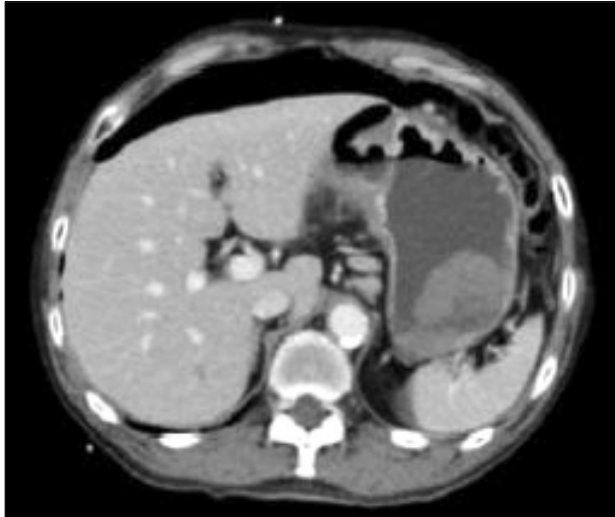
Computed tomography of Abdomen and Pelvis, showing gross pneumoperitoneum and likely site of perforation.
